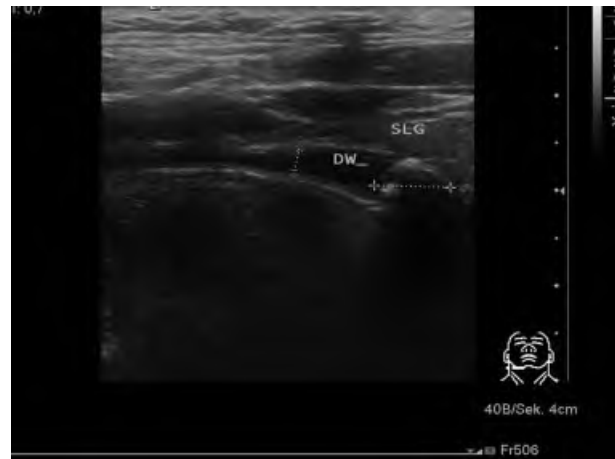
Sialolithiasis of the right submandibular gland. Oblique sonogram of the right submandibular gland shows the calculus (calipers) blocking the distended duct (DW). Abbreviation: SLG, sublingual gland.
